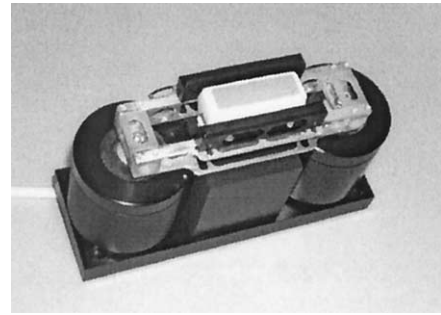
Low-frequency vibrating device composed of two parallel rods, two vibrators and an ultrasonic array.
